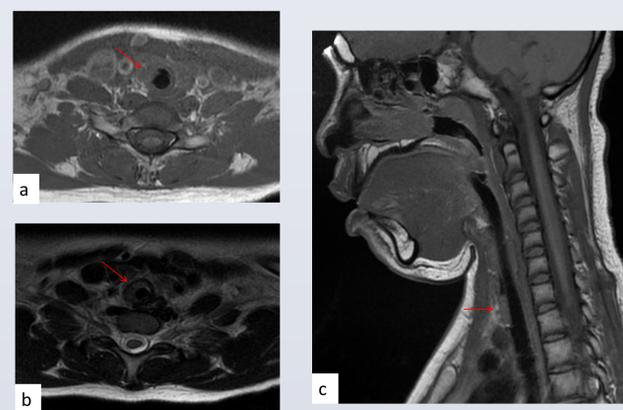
MRI of tracheal mass with patient intubated; arrows denote mass. a) Axial T1 weighted MRI; b) Axial T2 weighted MRI; c) Sagittal T1 weighted MRI.
